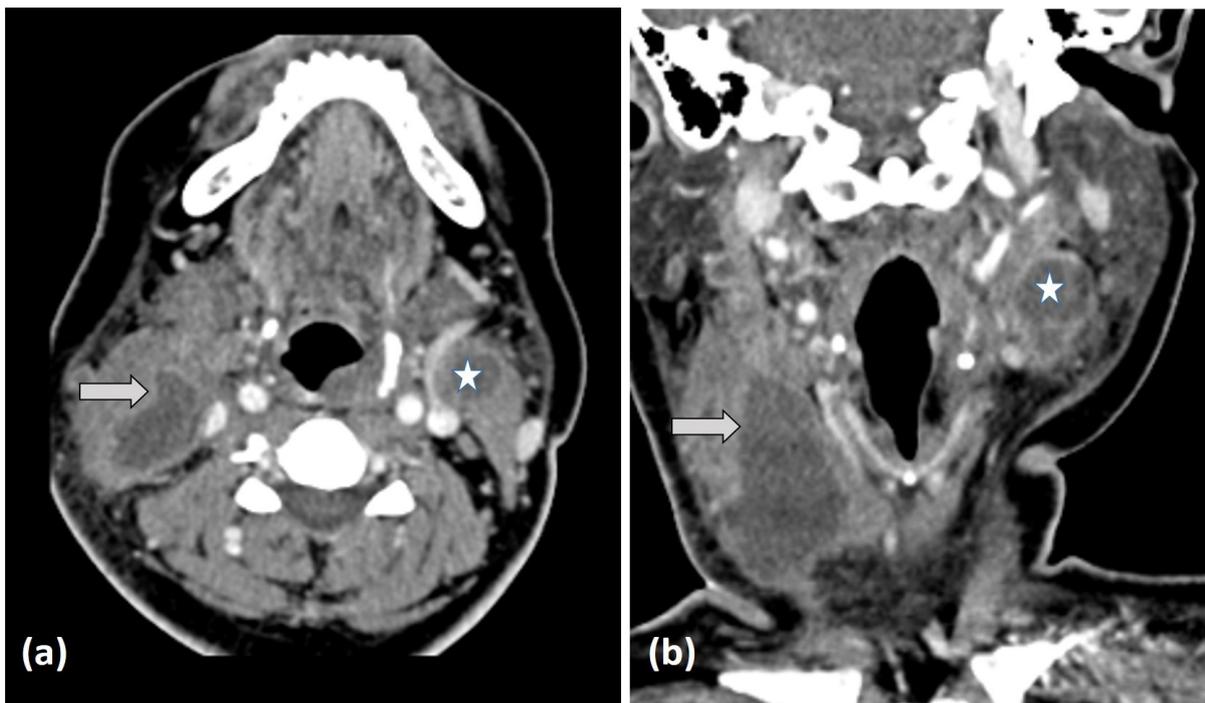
Axial (a) and Coronal (b) section of CT scan of the neck showing larger right sided abscess (straight arrow) and smaller left sided abscess (white star).
